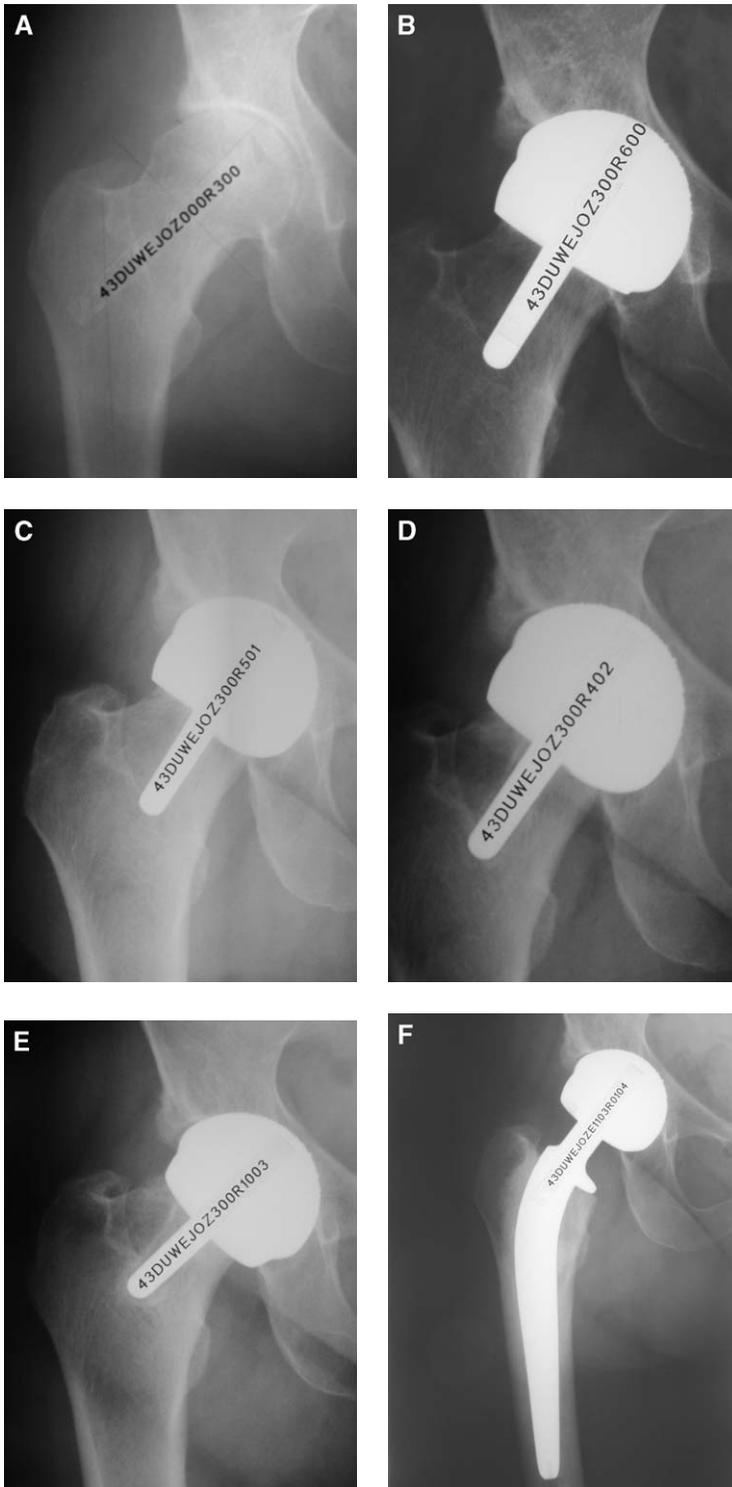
Radiographs showing avascular necrosis of the head. (A) Preoperative. (B) Nine months postoperative. (C) One year postoperative. (D) Two years postoperative. (E) Three years postoperative. (F) Revision. Note the changing reactive line at the metaphyseal stem of the prosthesis (Amstutz et al's [11] peg zone 1).
